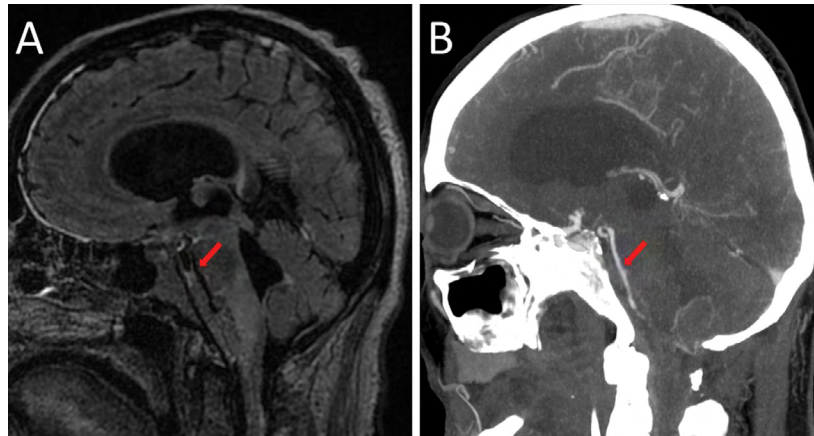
(A) Sagittal fluid-attenuated inversion recovery image demonstrating the full extent of abnormal signal material throughout the pre-pontine cistern, surrounding the expected course of the basilar artery; (B) sagittal reconstruction of a computed tomography angiogram demonstrating multifocal luminal caliber narrowing of the basilar artery
